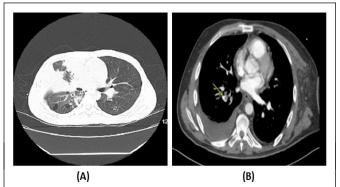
Combination of infectious and thromboembolic pathology in the lungs. Note: (A) Computed Tomography (CT) chest without contrast showing right upper lobe consolidation with associated air bronchograms, $6 \text{ cm} \times 4.5 \text{ cm}$ cavitary thick-walled lesion within the right upper lobe, right perihilar consolidation; (B) Computerized Tomography Pulmonary Angiogram (CTPA) showed acute pulmonary embolus in the right pulmonary artery.
